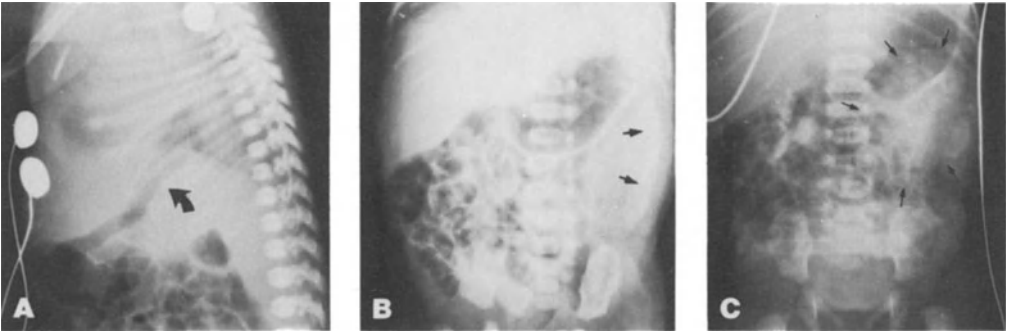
A. Lateral chest radiograph on a neonate with mild respiratory distress because of eventration of the left hemidiaphragm. There is a mass effect on the posterior aspect of the stomach (arrow) although a mass was not suspected clinically. B. Anteroposterior radiograph of an intravenous urogram at one minute in the same patient shows contrast in a rim of renal parenchyma (arrows). The kidney is enlarged and the two hour delayed view, C., shows opacification of the markedly dilated pelvocalyceal system (arrows)--hydronephrosis in this case secondary to ureteropelvic junction obstruction.
